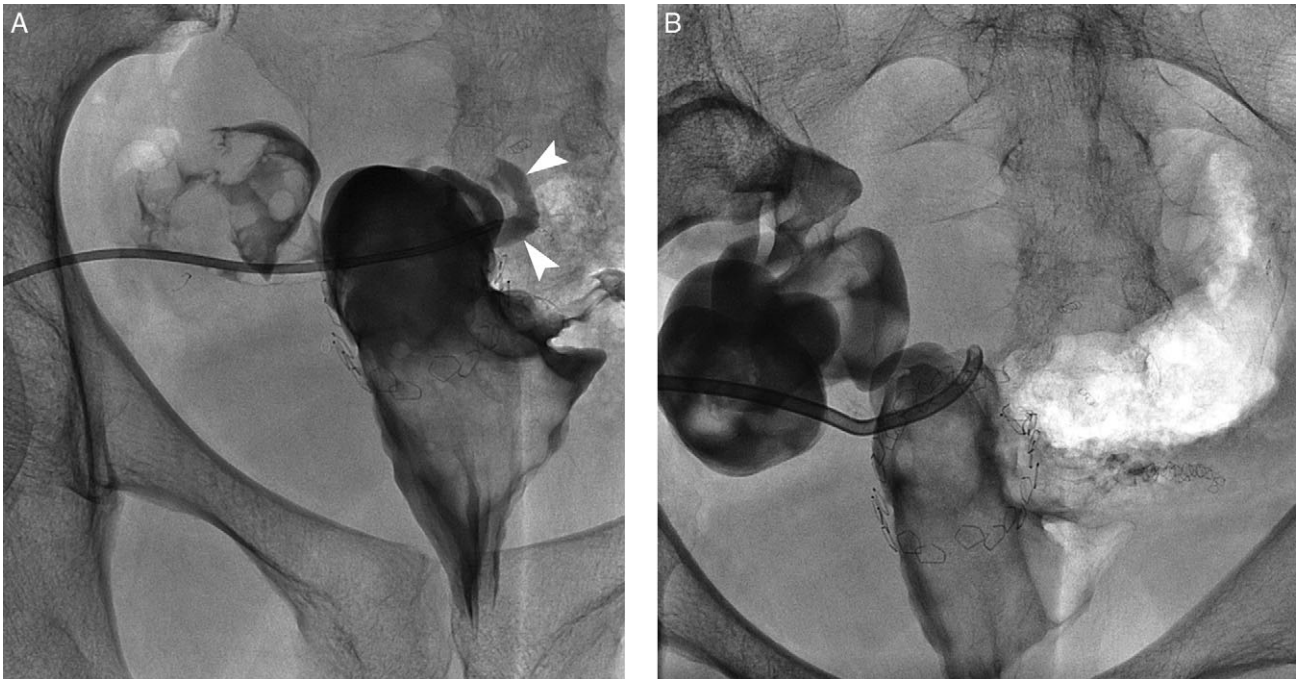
Radiographs of the pelvis obtained during fistulography and fibrin sealant administration. (A) Contrast injection of the fistula showed a mature thin tract (arrowheads) to the rectosigmoid without any residual abscess cavity (arrow). (B) After administration of the fibrin sealant, a drain was left in place away from the anastomosis to avoid disruption of the fibrin plug at the site of anastomotic leak. The fibrin sealant is not visible because it is radiolucent.
